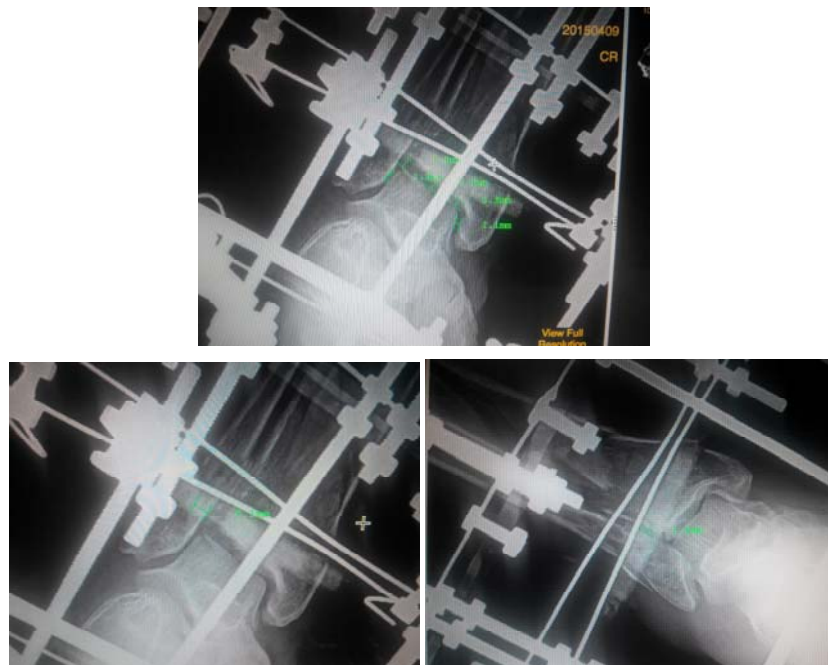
Xray with measurements as per Teeny-Wiss scoring
